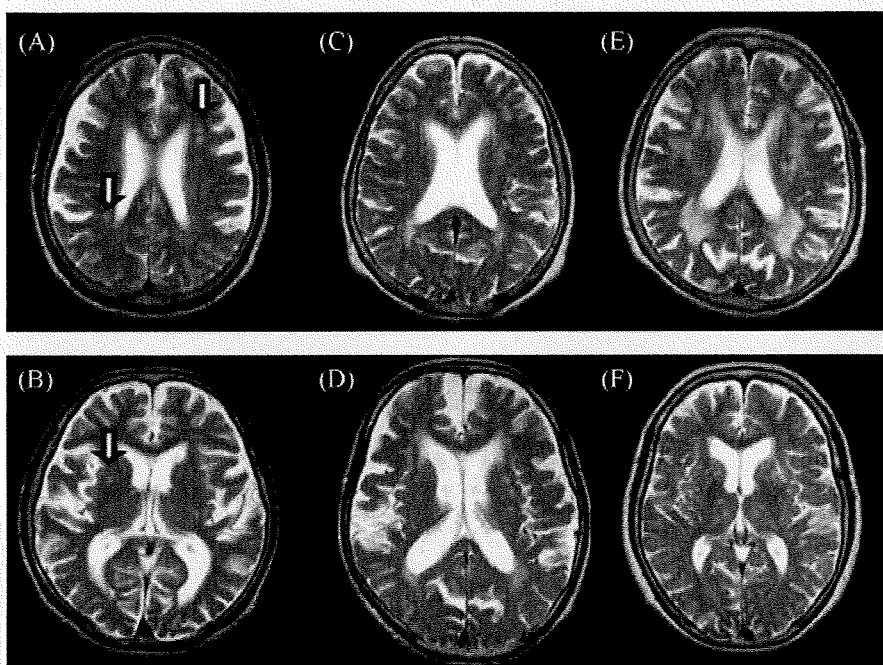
(a–f) Examples of rating scores 1, 2, and 3 on cerebral T2-weighted imaging. For a rating score of 1, a single lesion is clearly seen in a and b. There are two lesions in the left frontal white matter and one lesion in the right parietal white matter on a (arrow). There is one right putamen lesion on b (arrow). Additional lesions lead to a score of 2, as exemplified in c and d. Rating score 3 is shown in e and f. Subcortical WMHs are shown in a, c, and e and basal ganglia WMHs are shown in b, d, and f. Definitions of rating scores: 0, no lesion; 1, focal lesions; 2, beginning confluence of lesions for white matter lesions and >1 focal lesion for basal ganglia lesions; 3, diffuse involvement of entire region for white matter lesions and confluent lesions for basal ganglia lesions.
